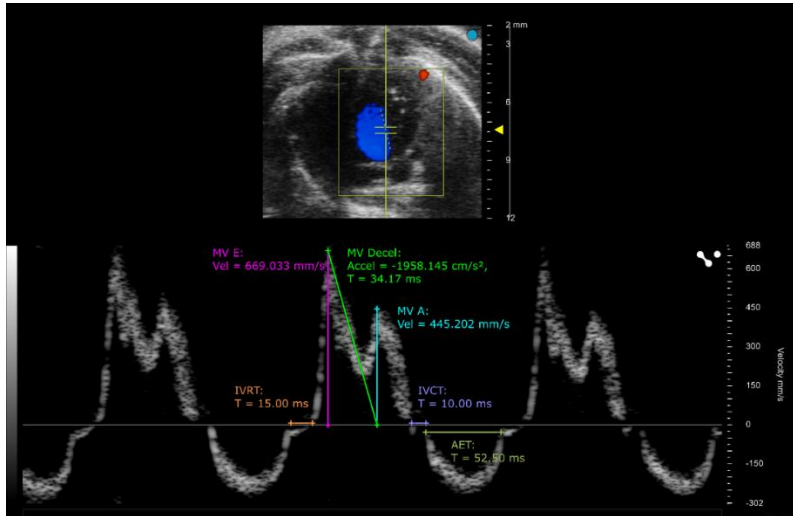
PW Doppler Mode waveform (and measurements) of mitral valve blood flow in the apical four chamber view.
